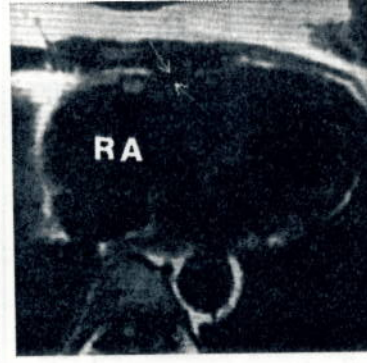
Constrictive Pericarditis. Contiguous transverse T1-weighted image of the heart shows a focal area of pericardial thickening (arrows) overlying the right ventricle and atrioventricular groove. The right atrium (RA) is enlarged.
